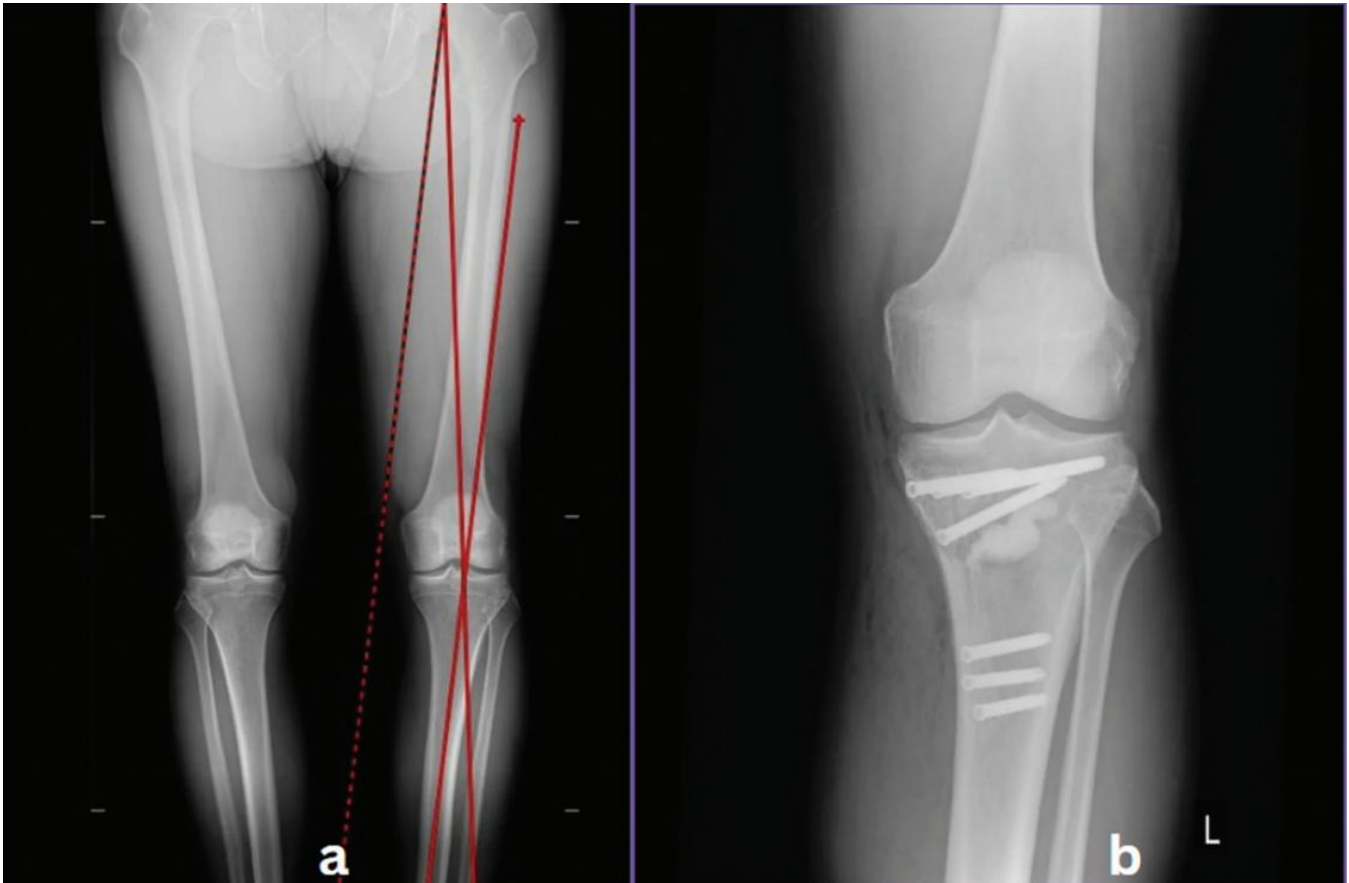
a) Preoperative x-ray demonstrating a varus deformity of the knee; b) postoperative x-ray following an open-wedge high tibial valgus osteotomy of the proximal tibia. (4)
